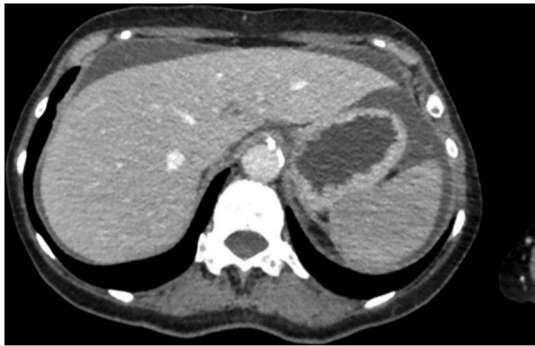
CT-scan of the patient showing ascites fluid in the perihepatic region.
